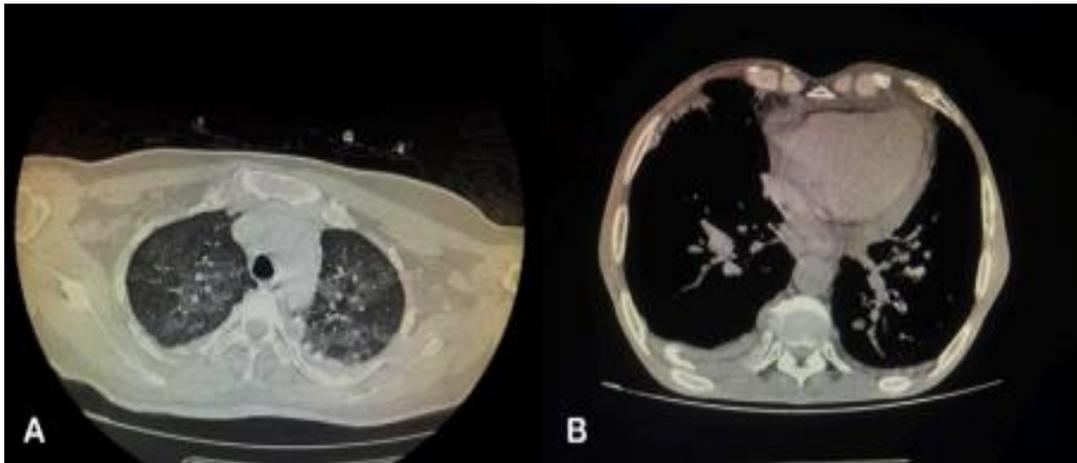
Noninjected chest CT scan objectifying moderate pulmonary parenchymal involvement typical of COVID (A) with low to moderate pericardial effusion (B)
